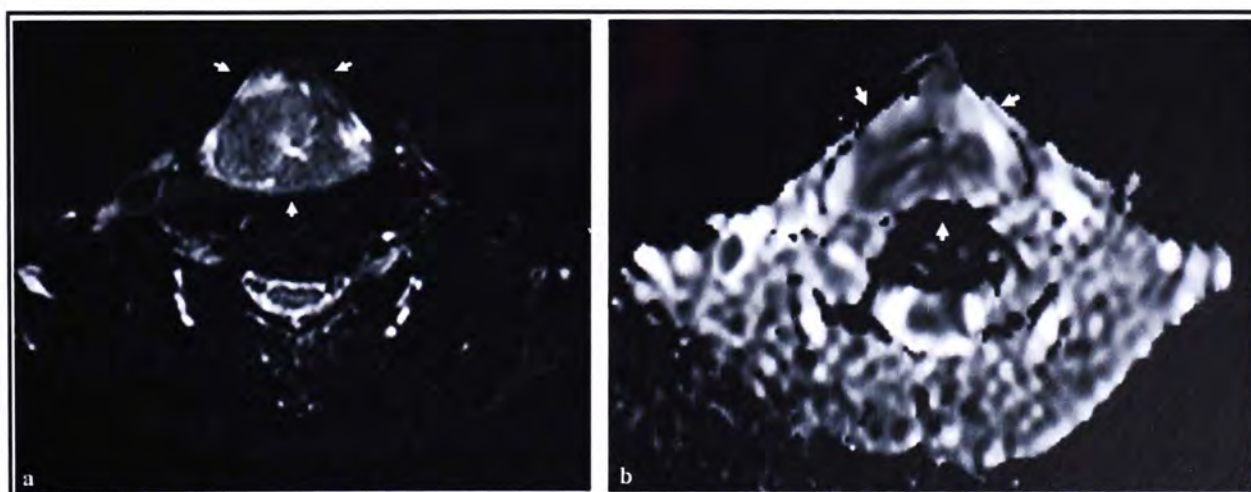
Primary SCC in a 63-year-old man. The Axial fat-suppressed T2W MR image (left) and ADC map (right) show the primary tumor (arrows) with ADC value of $1.10 \pm 0.324 \times 10^{-3} \text{ mm}^2/\text{s}$.
